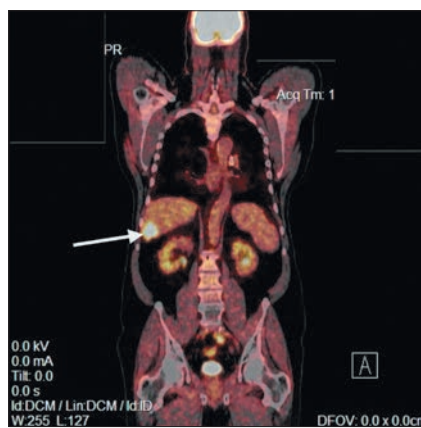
Fused PET/CT scan showing uptake in a liver secondary tumour (arrow).
